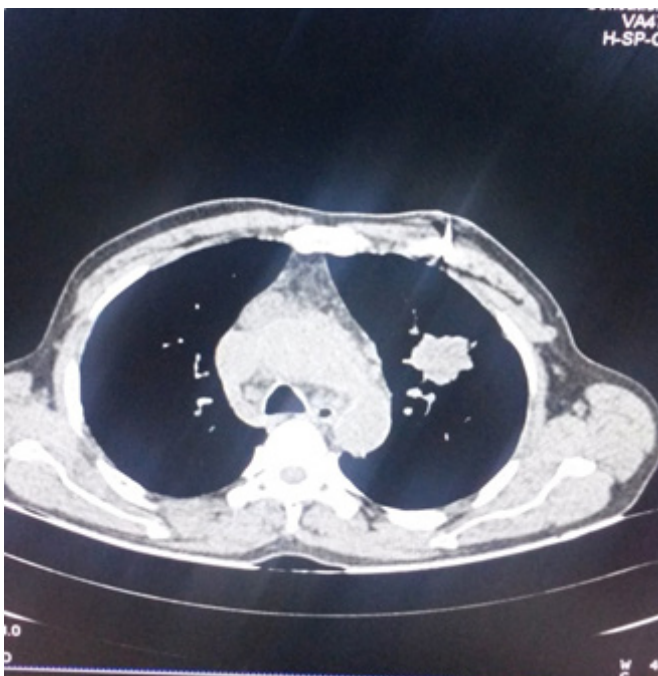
CT image shows well defined soft tissue mass in left upper lobe
